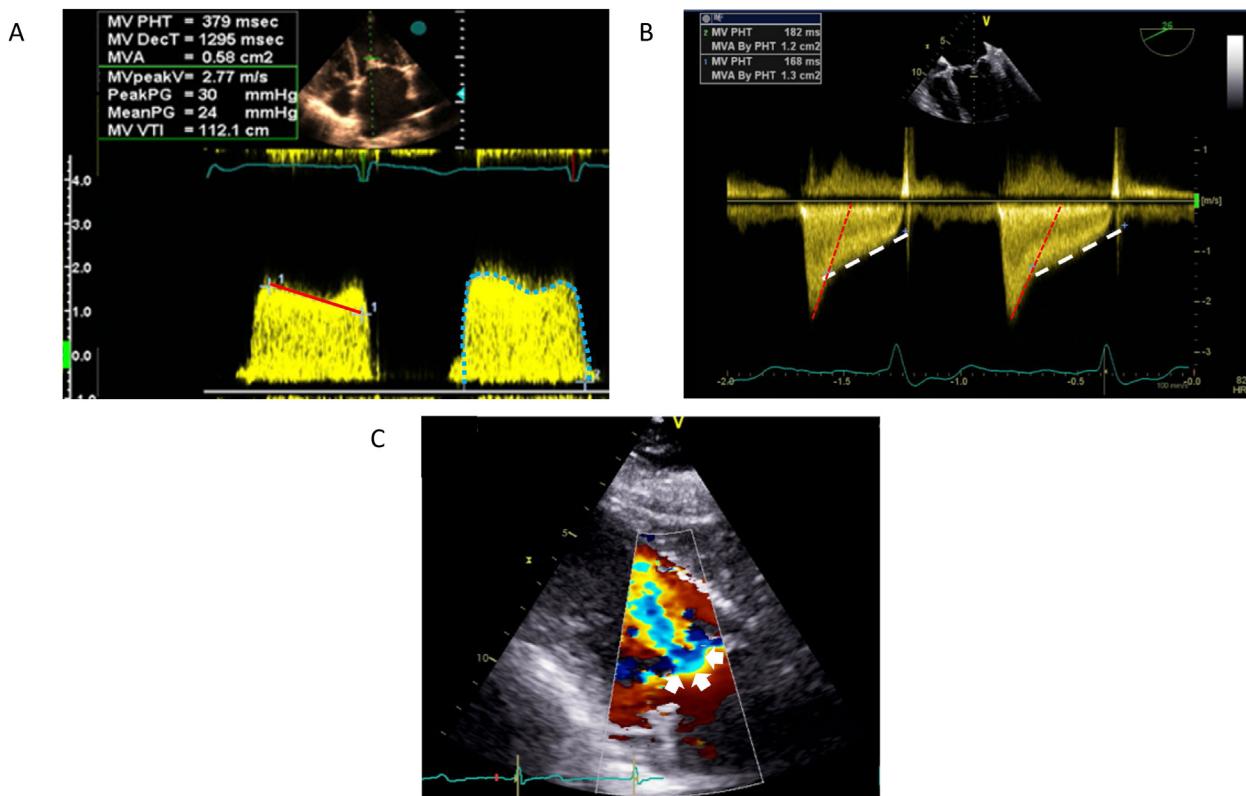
Examples of Doppler echocardiography in MS. (A) Continuous-wave Doppler waveform of mitral inflow in severe MS, demonstrating long PHT (red line) leading to reduced MVA calculated from PHT, and elevated mean gradient (24 mmHg) derived from the VTI (in blue dotted outline) of mitral inflow. (B) When the deceleration slope of the MV inflow is biphasic with a rapid decay (red line) followed by a more gradual decay, the deceleration slope should be traced in mid-diastole (white line) rather than using the early steep deceleration slope. (C) Color Doppler of the MV in diastole indicating the acceleration of flow toward the stenotic orifice and hemispherical isovelocity surface "shells" (white arrows) formed at the stenotic MV.
